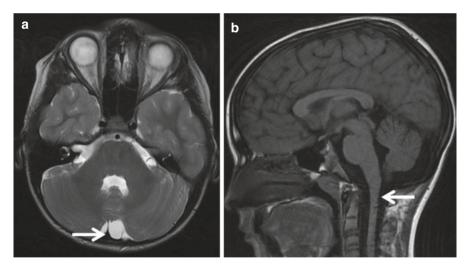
Biochemical testing noted serum CK 344 U/L (normal <175 U/L). MRI brain (Fig. 25.3) identified a small mid-line subarachnoid cyst in the posterior fossa (a; arrow) that was determined to be an incidental finding. There was no cerebellar atrophy, although later re-examination did show mild thinning of the cervical spinal cord (b; *arrow*)
